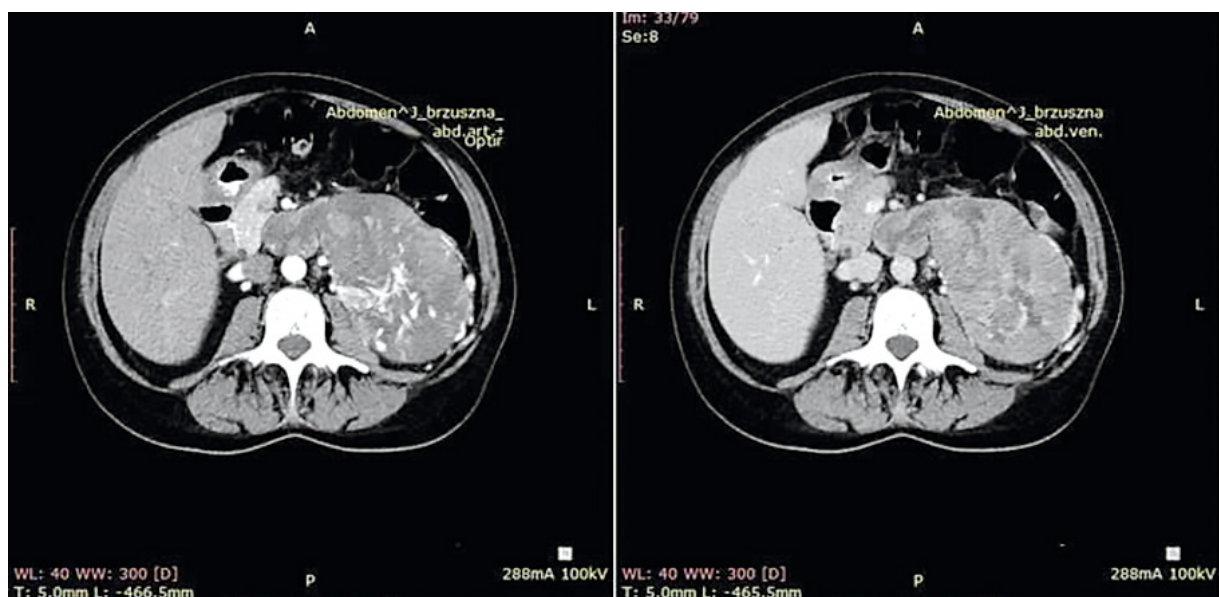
Abdomen CT. Left adrenal gland tumor. Infiltration of left renal vein, vena cava inferior and left kidney
